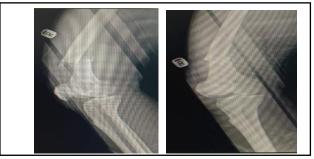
Right femur radiographs
